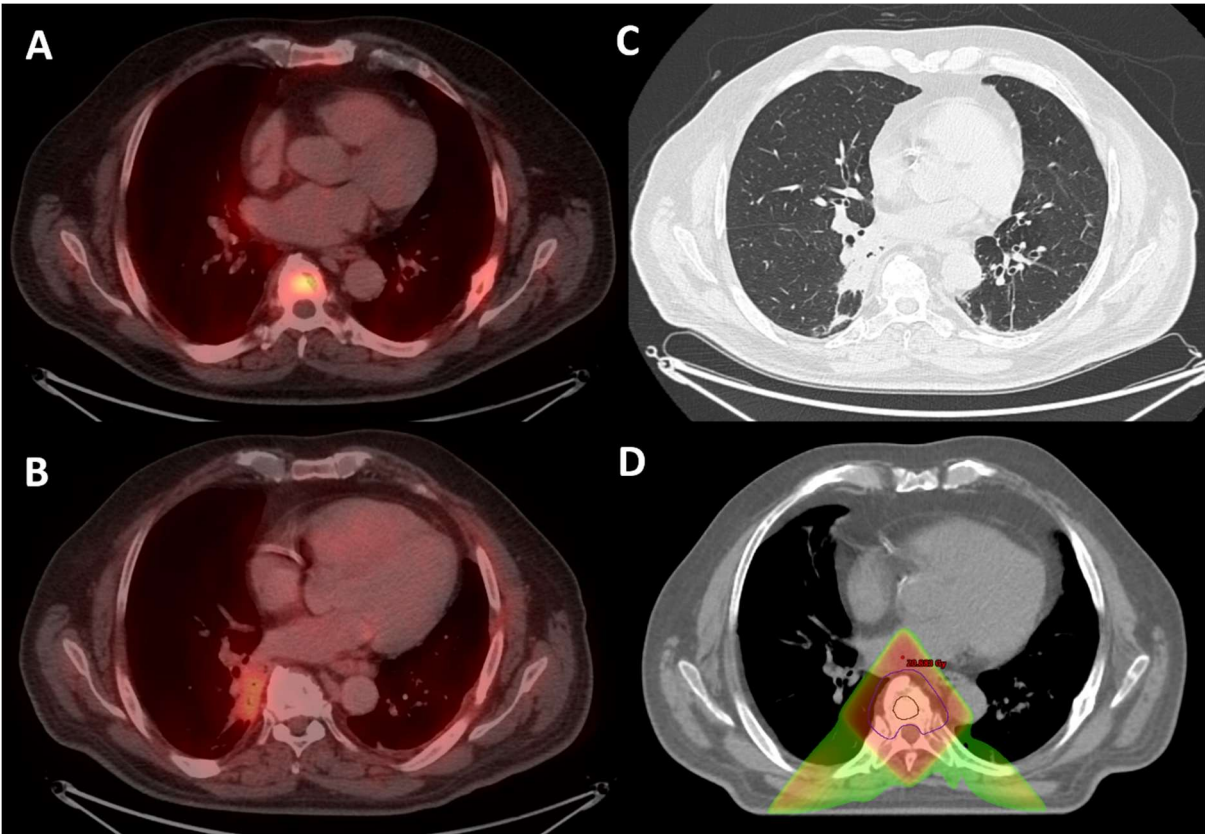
A 68-year-old male with metastatic castration-resistant prostate cancer had a partial response to Carboplatin and Taxotere and received palliative radiation-therapy, 20 Gy in 5 fractions, to a dorsal vertebral (D7) metastasis positive on 18F-PSMA PET-CT (figure A). PSA serum levels dropped from 65 to 0.06 ng/mL. Four months later, on routine follow-up, a 18F-PSMA PET-CT scan showed increased mild uptake (figure B) in a new paravertebral lung consolidation/mass measuring 4x2 cm in the right lower lobe (figure C).
